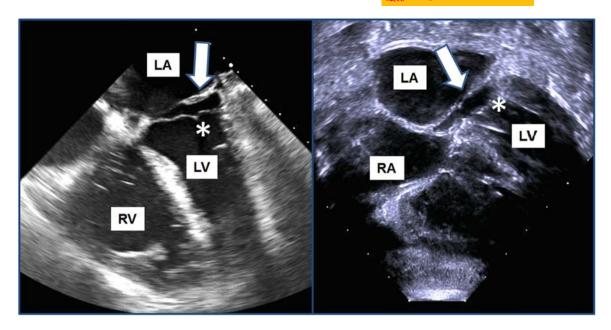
Echocardiographic images of cor triatriatum sinister (CTS). Left: Transesophageal echocardiogram (mid-esophageal level) showing CTS membrane (white arrow) in the left atrium above the mitral valve (asterisk). Right: Transthoracic echocardiogram (subcostal window) showing CTS membrane (white arrow) in the left atrium above the mitral valve (asterisk). Abbreviations: LA, left atrium, RA: right atrium, IV, left ventricle, rV, right ventricle
